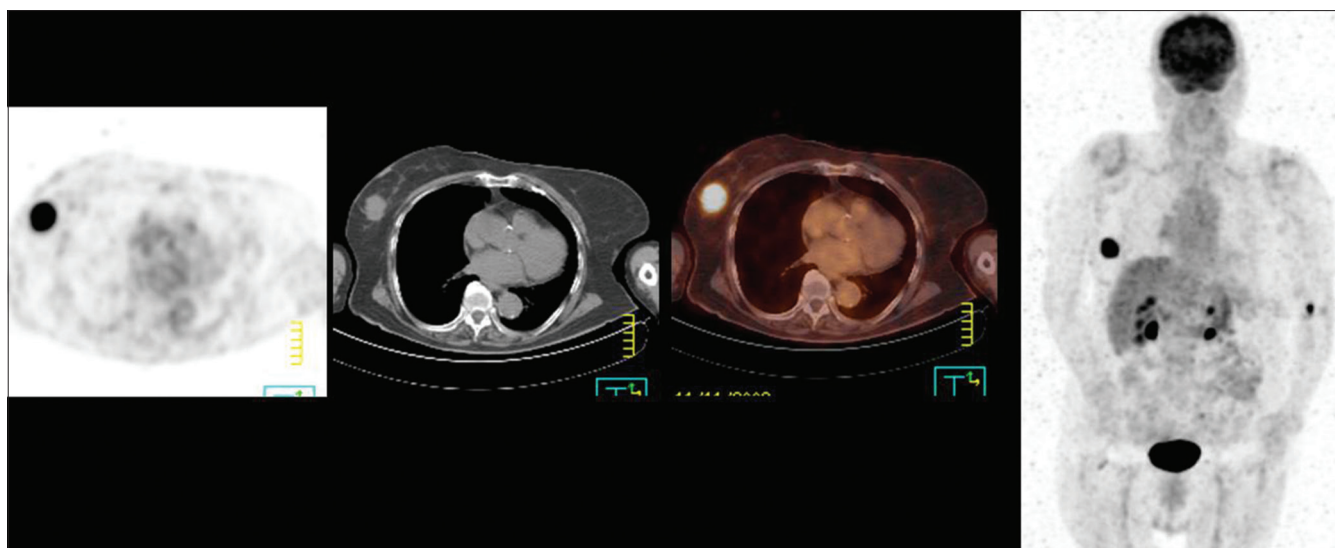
Right breast invasive ductal and triple-negative breast carcinoma (size 4.5 × 4 cm) and SUVmax: 14 (Reprinted with permission from Basu *et al.*^[8])
